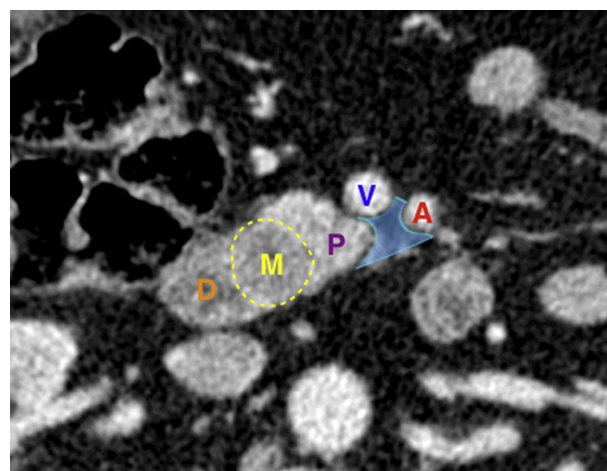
Anatomic representation of the retroperitoneal margin through the pancreatic head and uncinate process on computed tomography image obtained in the transverse plane during the portal venous phase following intravenous administration of iodinated contrast material. Retroperitoneal margin (or retroportal) is determined by the cellular-fatty space between the left border of the uncinate process and the superior mesenteric artery (since its origin), behind the mesenteric-portal veins. Some authors associate also the cellular-fatty space located behind the pancreas head and in front of large retro-peritoneal vessels (inferior vena cava and aorta). (D: duodenum; M: tumor mass of the pancreatic head; P: pancreatic head; V: superior mesenteric vein; A: superior mesenteric artery; Light blue area, retroperitoneal margin).
